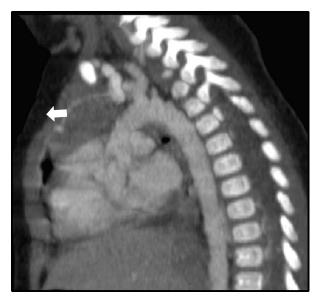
Sagittal reconstruction of a chest CT showing a bicarotid trunk (arrow)
